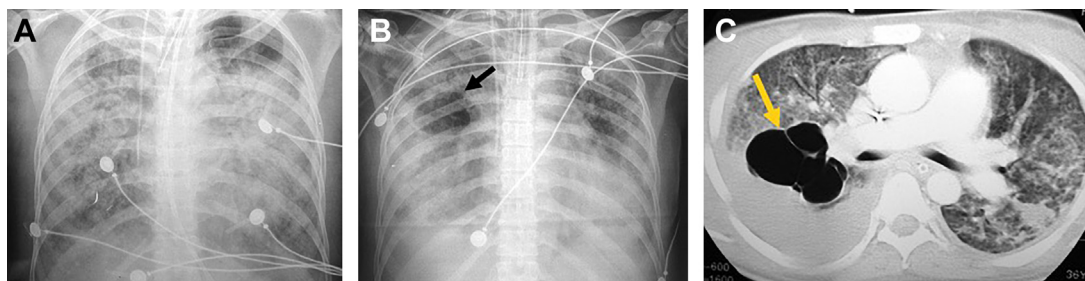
Methicillin-resistant *Staphylococcus aureus*. (A) Portable chest radiograph shows extensive bilateral dense consolidations in upper lobes. (B) Follow-up radiograph shows a well-defined air-collection in the upper right lung (arrow). (C) CT shows a pneumatocele in the upper right lobe (arrow). A right pleural effusion is also demonstrated. Community-acquired methicillin-resistant *S. aureus* pneumonia was diagnosed.
